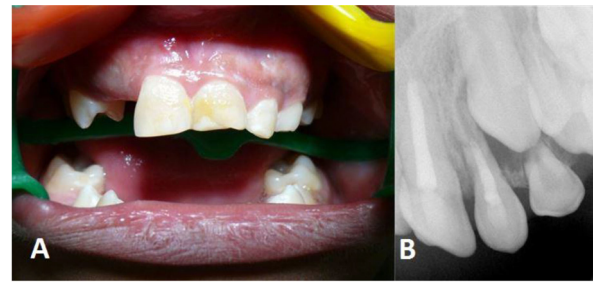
A) Follow-up photograph after 24 months. B) Follow-up radiography of maxillary left lateral incisor after 24 months
